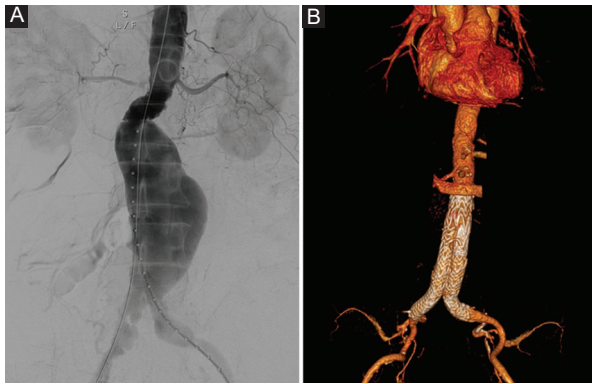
A: diagnostic angiography demonstrating the presence of an infrarenal AAA. B: computed tomography 3D volume rendering after EVAR showing no stent-graft migration, limb occlusion, or endoleak.
